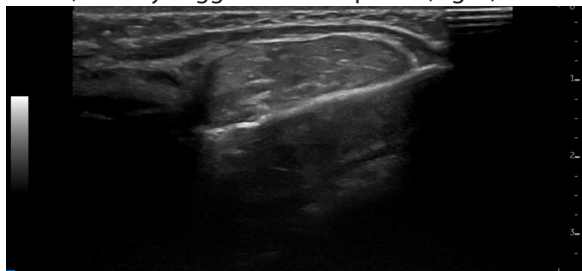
Ultrasonographic image depicting a well-defined hypoechoic mass consistent with a lipoma.
